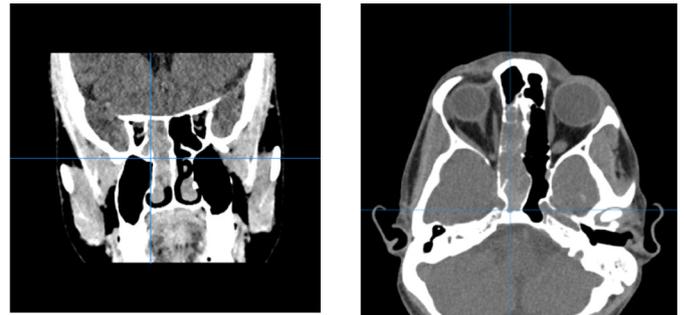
CT PNS with contrast showing extension of the tumour in the anterior and posterior ethmoid sinuses and sphenoid sinus on the right side.
